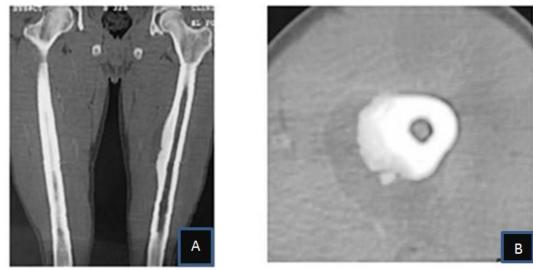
The CT showed a well-circumscribed tumor lying on the outer surface of the cortex associated with irregular thickened cortical. A: coronal section, B: axial section
